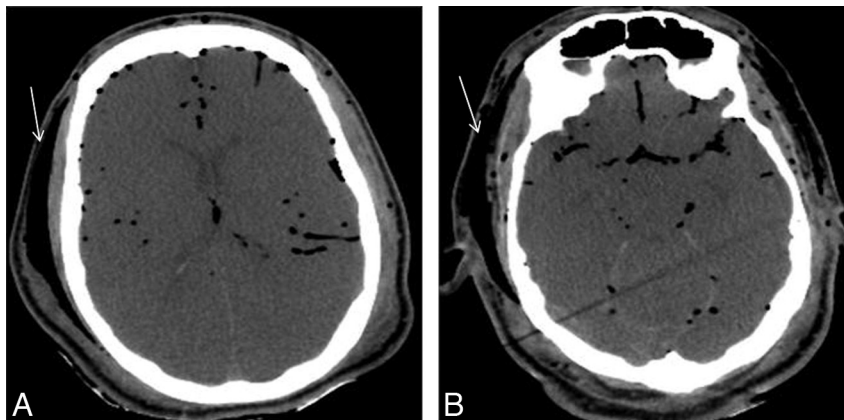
Vascular air. Axial noncontrast CT images demonstrate air within both the arterial and venous structures, which is relatively symmetrically distributed. In addition, air is seen within the subcutaneous tissues (arrows).
